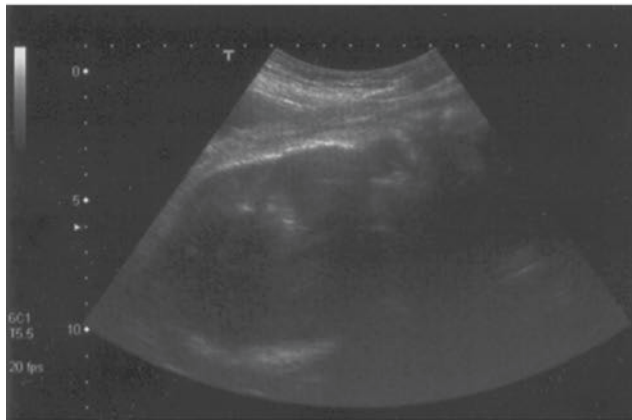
Operative vaginal delivery in a protracted second stage of labour for fetal head in right occiput posterior position: on the left, the ultrasonographic scan showing the left orbit (the squint sign) and anterior asynclitism, and on the right, the corresponding draw
